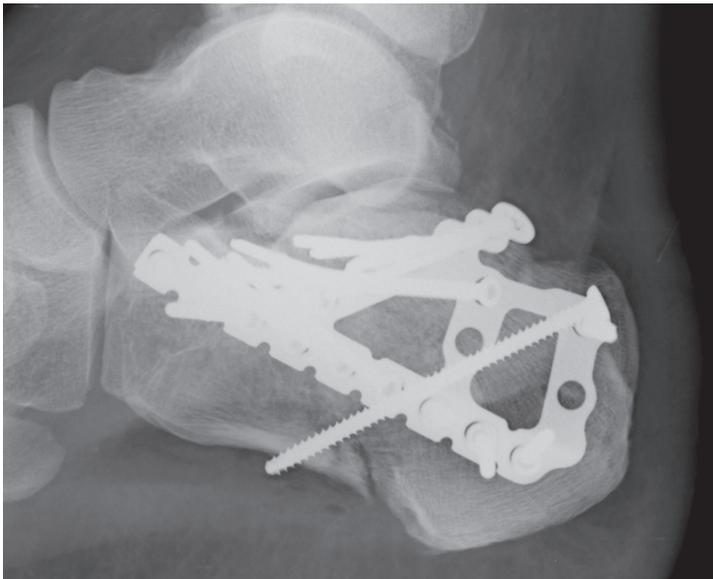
Injury radiograph. 1b. Post-surgical radiograph
